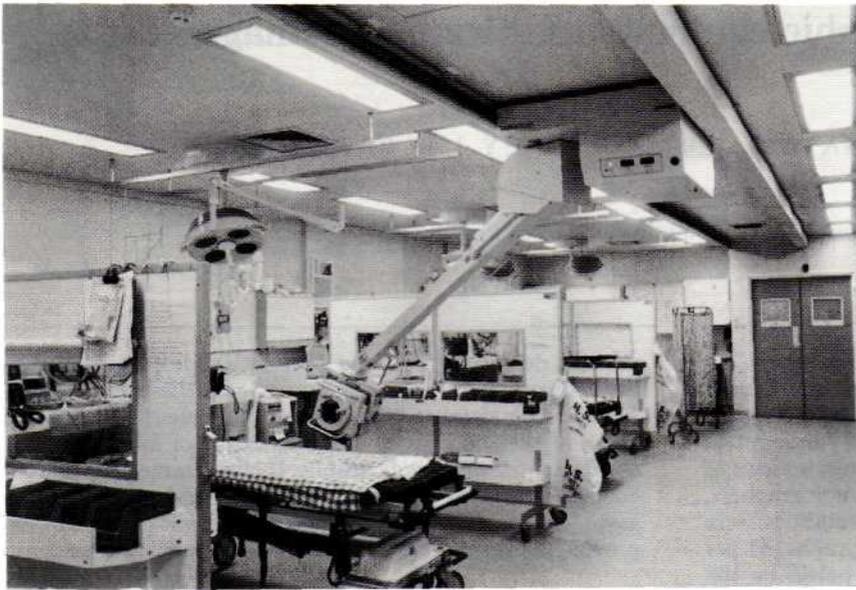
Resuscitation room (part of the Helicopter Emergency Medical Service and Trauma Unit) in the Royal London Hospital with ceiling-mounted radiographic machine and individual resuscitation bays
